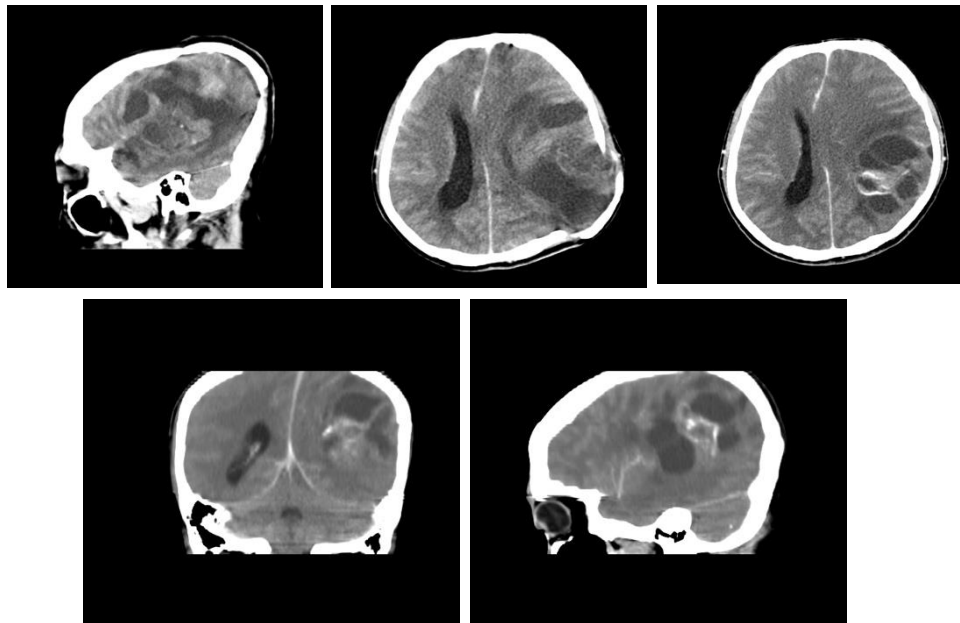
Head CT scan with Contrast
